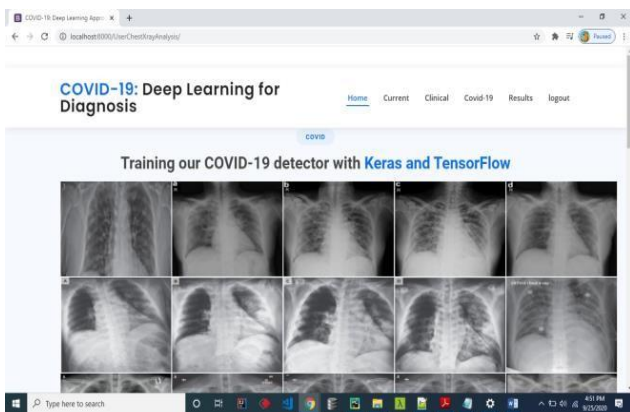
Chest X-ray image
